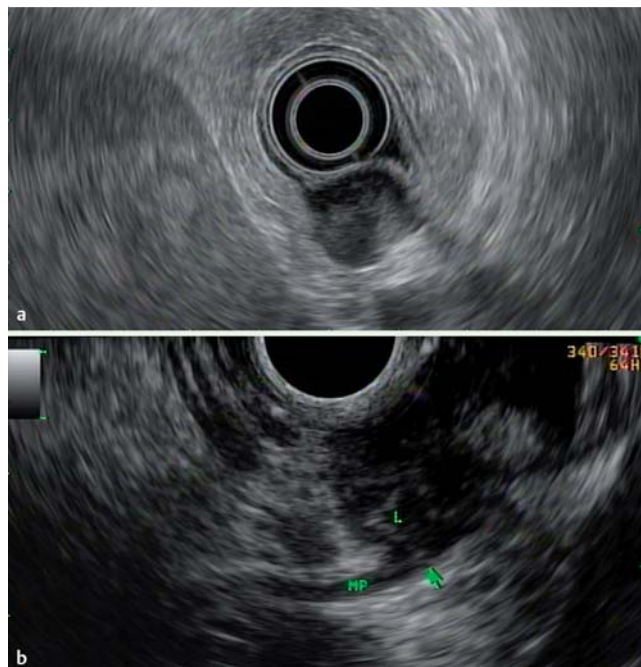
Endoscopic ultrasound images.
